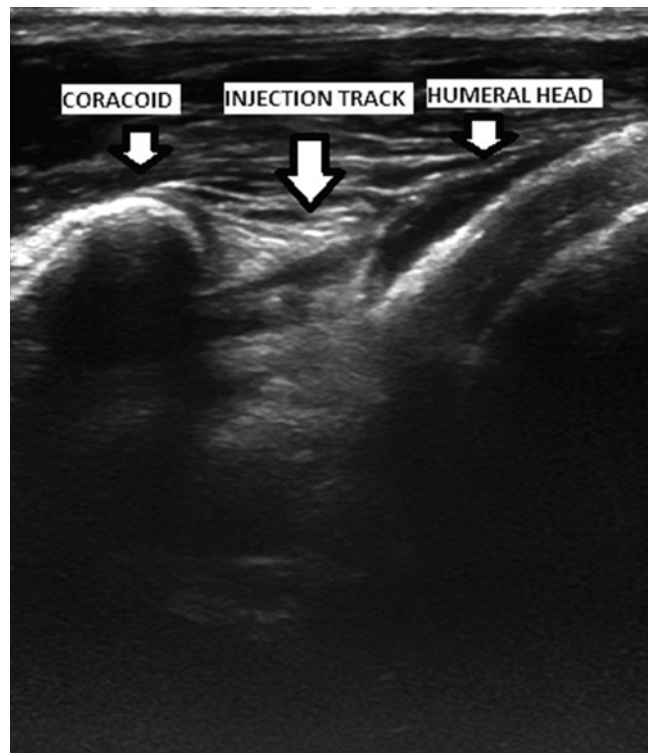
Ultrasound image of the injection track midway between the tip of the coracoid and the bicipital groove
